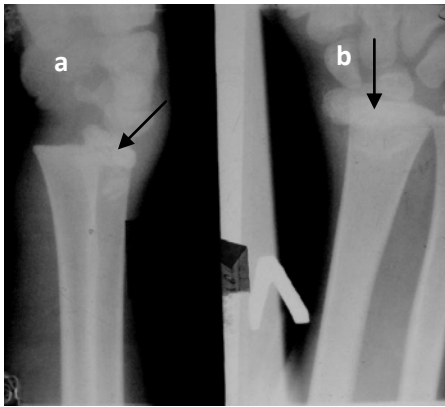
The radiograph of the left radiocarpal joint in lateral (a) and direct (b) projections of a 14-year-old child. In direct and lateral projections there is a displacement of radial bone ectad and entad (arrows). Traumatic epiphysiolysis with radial bone distal epiphysis displacement
